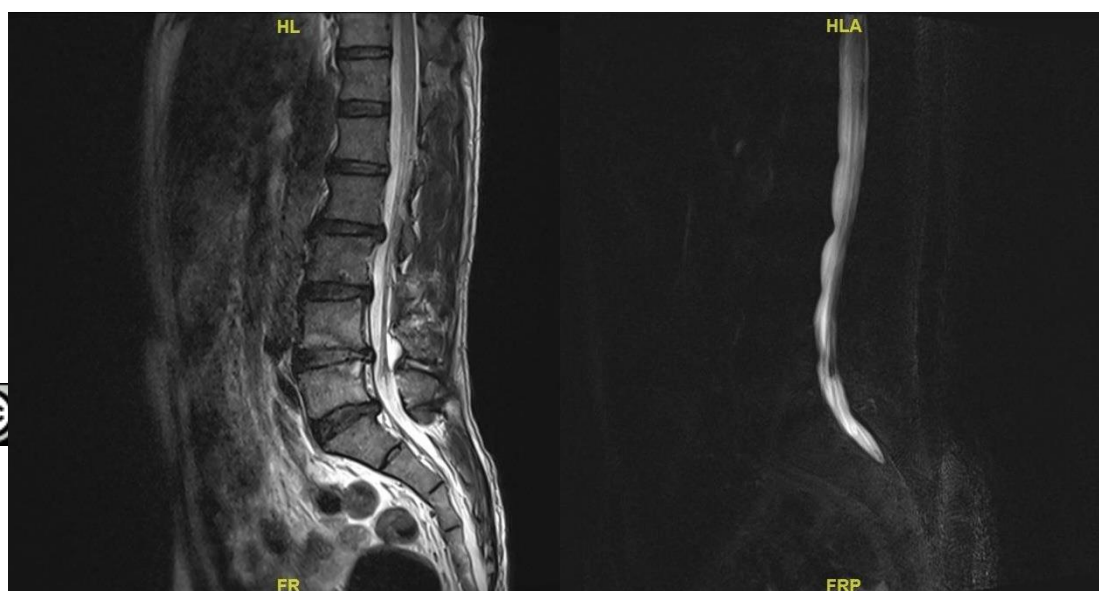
Plain Lumbar MRI
